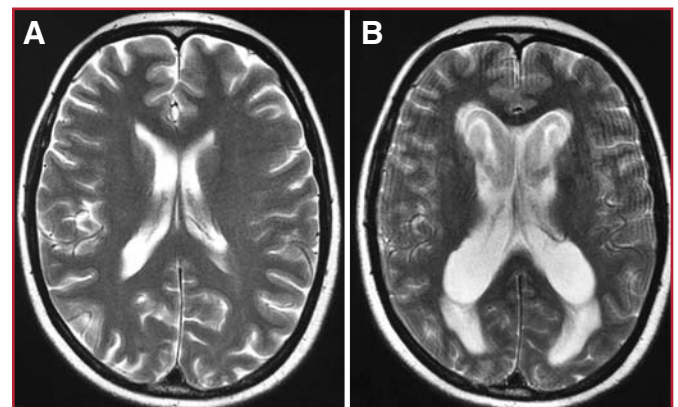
Pre- (A) and postoperative (B) T2-weighted magnetic resonance images showing a significant increase in ventricular size after endovascular coiling.
